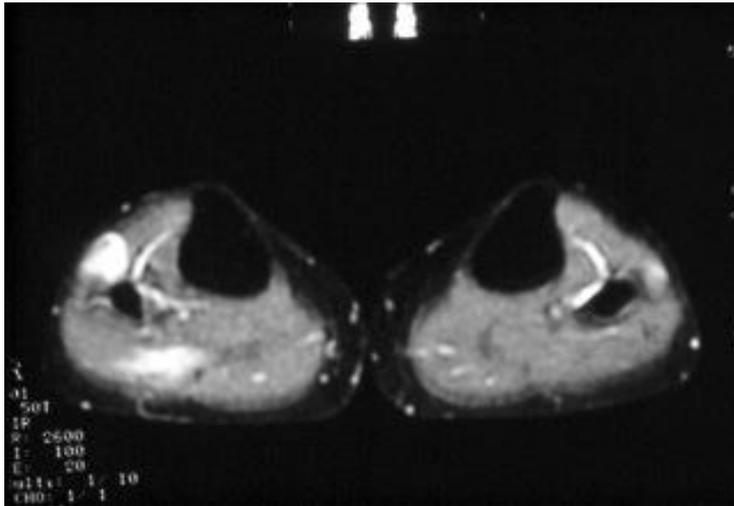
Peroneus muscle hyperintense signals on T₂-weighted MRI in a PAN patient with skeletal muscle involvement.
